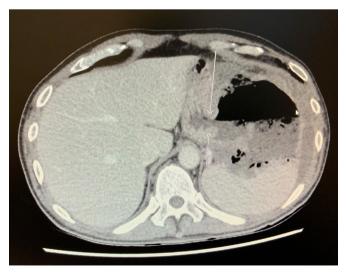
Axial image of the abdomen on a CT scan with intravenous contrast—fistulous tract between the stomach and the spleen (white arrows).
